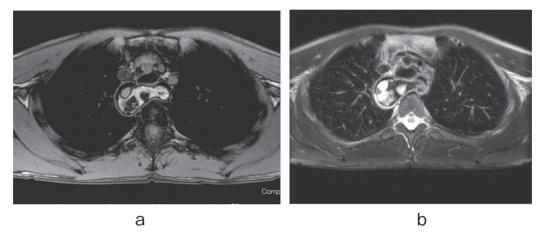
Magnetic resonance imaging: a) T1-weighted image and b) T2-weighted image
